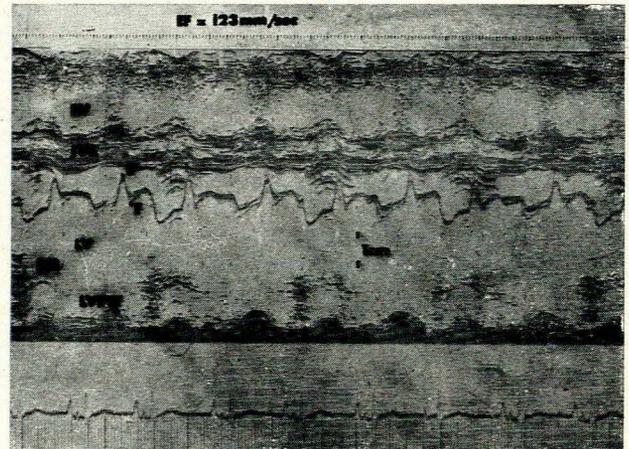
Echocardiogram showing paradoxical septal wall motion with 'flattening' of the left ventricular endocardial wall motion during diastole. The 'mitral valve slope' (E-F) is normal. There is no pericardial effusion (RV = right ventricle; IVS = interventricular septum; LV = left ventricle; PM = papillary muscle; LVPW = left ventricular posterior wall).
